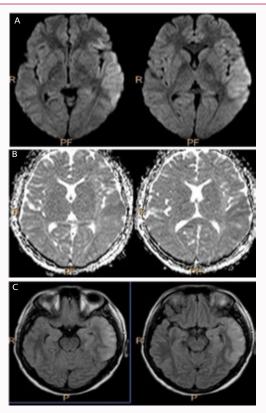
MRI brain showing diffusion restriction in DWI in Left insular cortex (A). ADC map showing low intensity signals at Left insular cortex (B) & T2 W FLAIR hyperintensity in Left medial temporal lobe (C).
